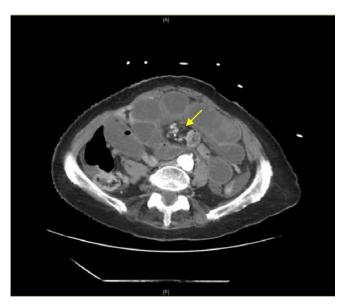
Computed tomography abdomen with intravenous contrast demonstrating dilated, fluid-filled loops of small bowel and a pattern of swirling mesenteric vessels called the whirlpool sign (arrow).
